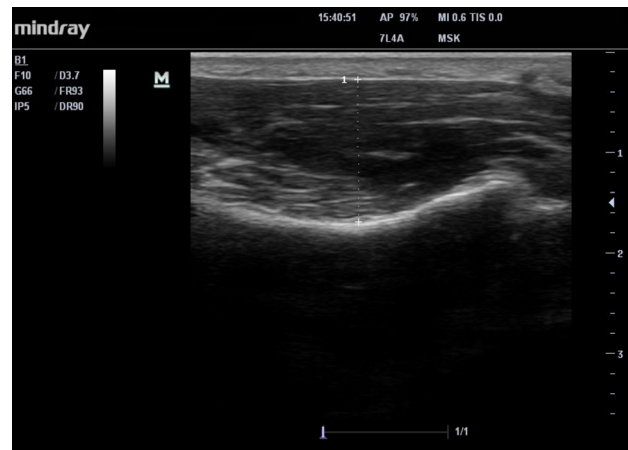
Thenar muscle thickness as measured by ultrasound
